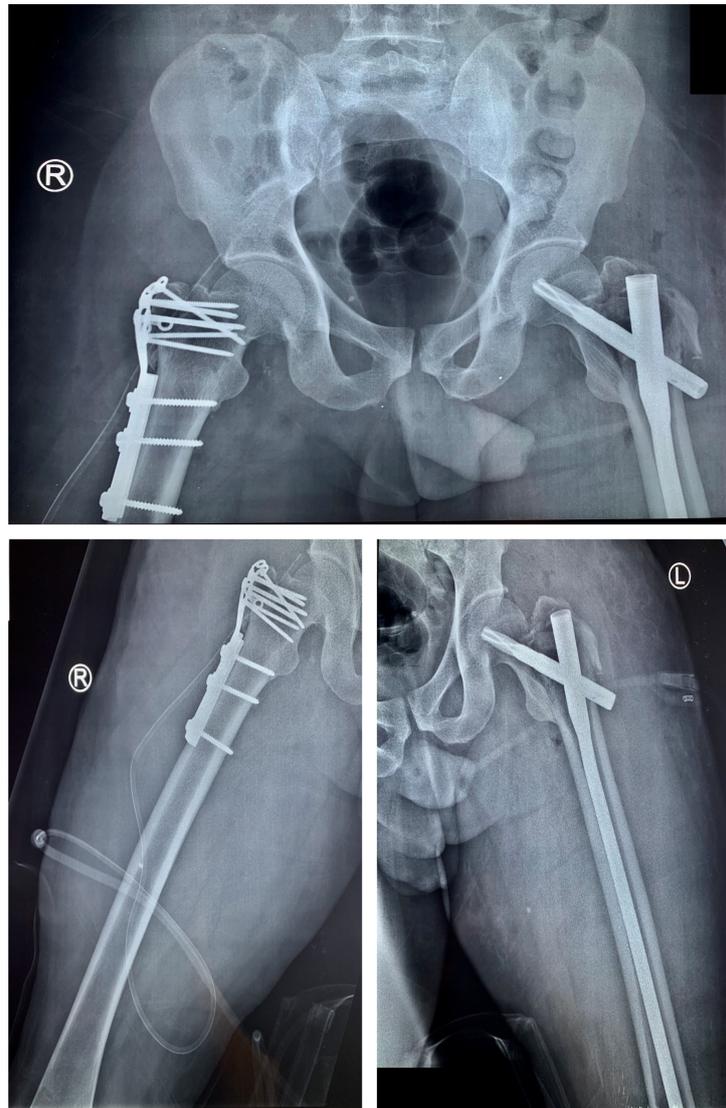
Postoperative pelvis radiograph (top), right femur with Universal Locking Trochanteric Stabilization Plate (bottom left), and left femur long proximal femoral nail (bottom right).
